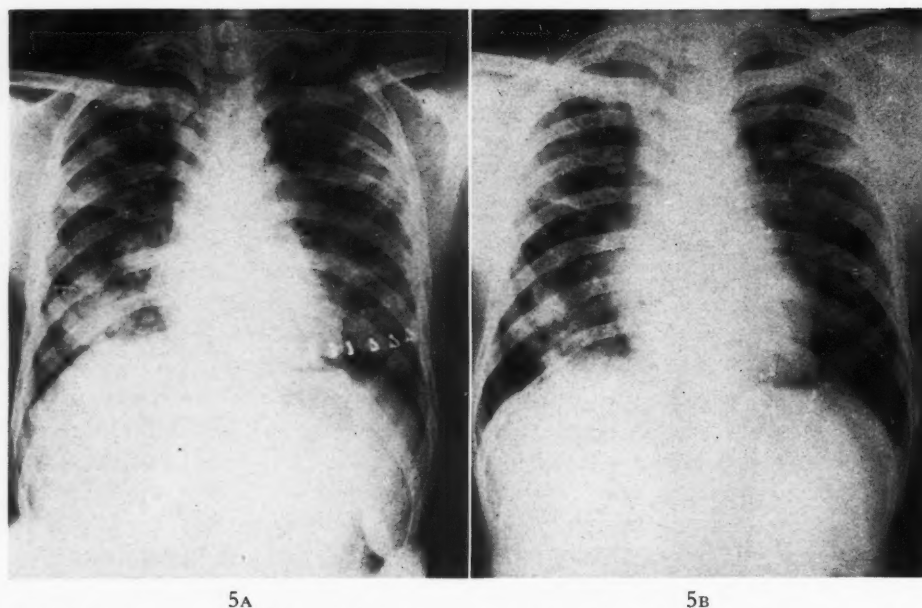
Case IX. A, x-ray of chest before treatment with cortisone showing diffuse infiltrations in both lungs with enlarged mediastinal lymph nodes; the metal clips are in the skin. They were placed there after lung biopsy, performed two days earlier. B, x-ray of chest of same patient after five weeks' treatment with cortisone showing clearing of many of the infiltrations and some shrinkage of the mediastinal nodes; there is residual streaking in both lung fields.
